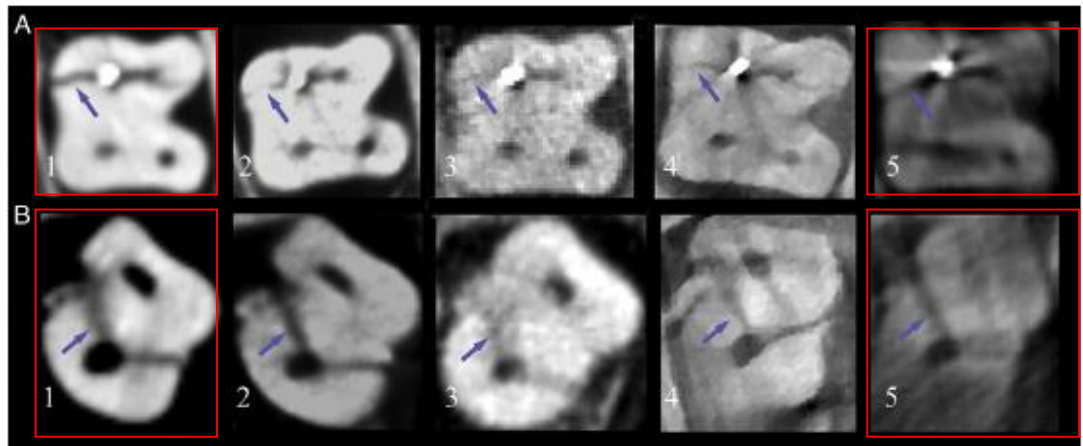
An example of an axial cross-section showing a vertical root fracture line (arrow) in an endodontically filled root (row A) and in a nonfilled root (row B). CBCT systems from left to right: (1) Next Generation i-CAT, (2) Scanora 3D, (3) NewTom 3G, (4) AccuTomo MFC-1, and (5) Galileos 3D.
